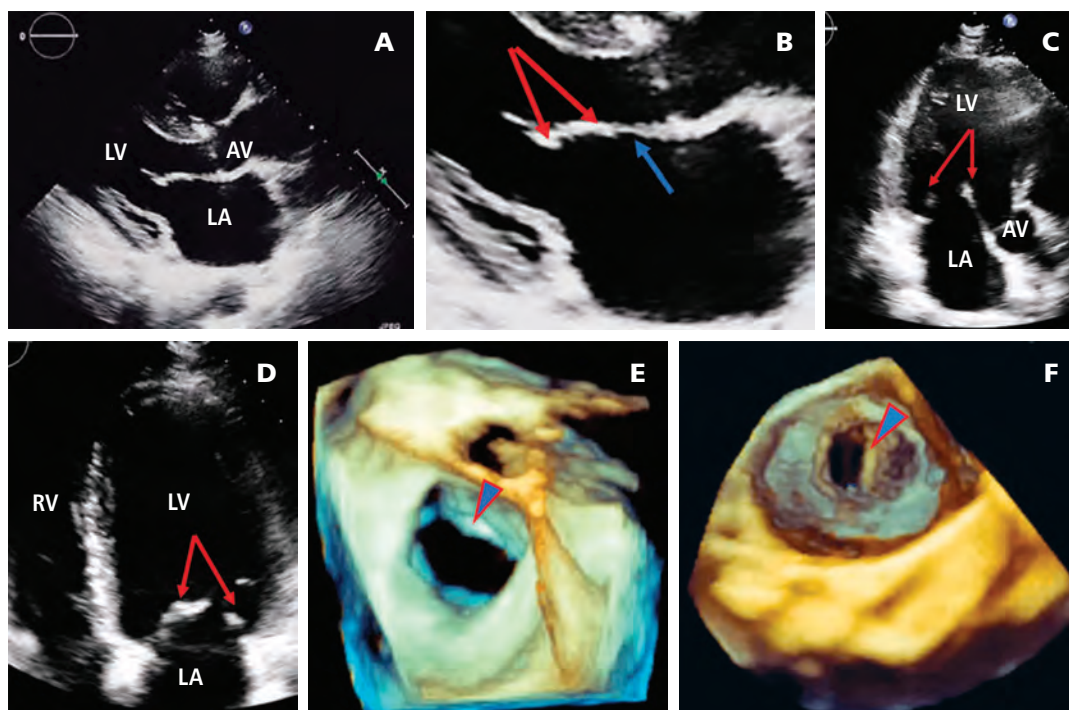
Echocardiographic analysis of explanted human valve in a patient with ischemic mitral regurgitation. A) 2D parasternal long axis shows increased length of the leaflets and dilation of the annulus (anterior leaflet 32 mm, posterior leaflet 22 mm, annulus in end diastole 39 mm). B) Approach to the mitral valve, the red arrows mark the thickening of the cusp and middle portion of the anterior leaflet (0.5 and 0.4 cm respectively) contrasting with the normal thickness of the base of the valve (0.2 cm) blue arrow. C and D) Apical long axis and four chambers showing the thickening of the cusps of the anterior and posterior leaflets in the same patient, red arrows. E) 3D echocardiography image of the mitral valve in face, arrow points to the site of distal thickening of the anterior leaflet. F) 3D echocardiography with approach from the ventricle. Note the anterior leaflet elongated, the posterior leaflet retracted, the arrow points to the site of distal valve thickening in anterior valve.
